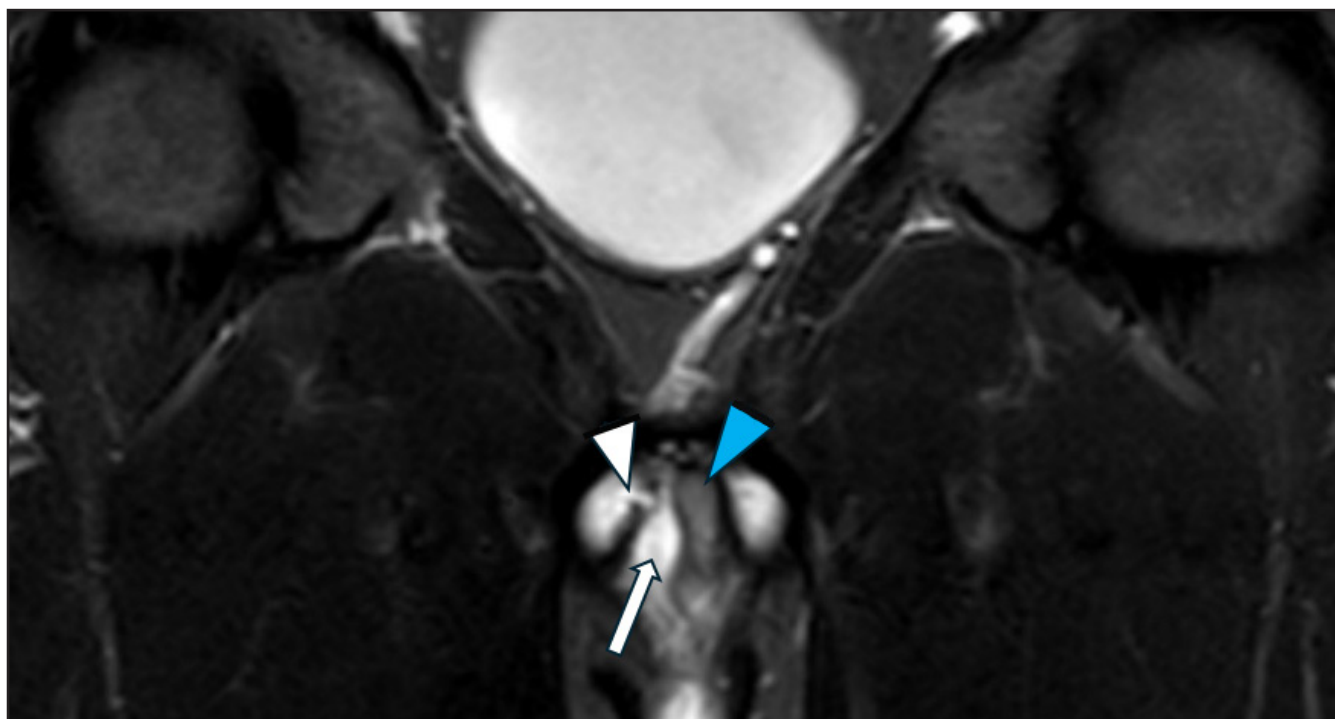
Coronal Short Tau Inversion Recovery (STIR) sequence MRI image of the base of the penis at the same position as on image 1, shows the small defect in tunica albuginea as an outpouching at the superomedial aspect of the right corpus cavernosum (white arrowhead). For better appreciation compare it with the normal looking left corpus cavernosum. The asymmetrical biconvex bright focus on the right (white arrow) is the associated haematoma and oedema which has mildly deviated the corpus spongiosum (blue arrowhead) to the left.
